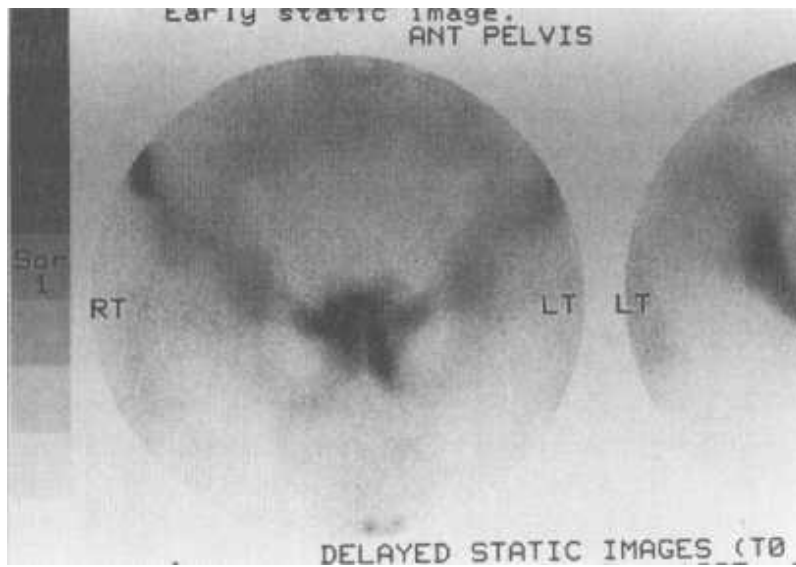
Typical scintigraphic bone scan appearance of obturator neuropathy (delayed phase of 99mTc bone scan).
